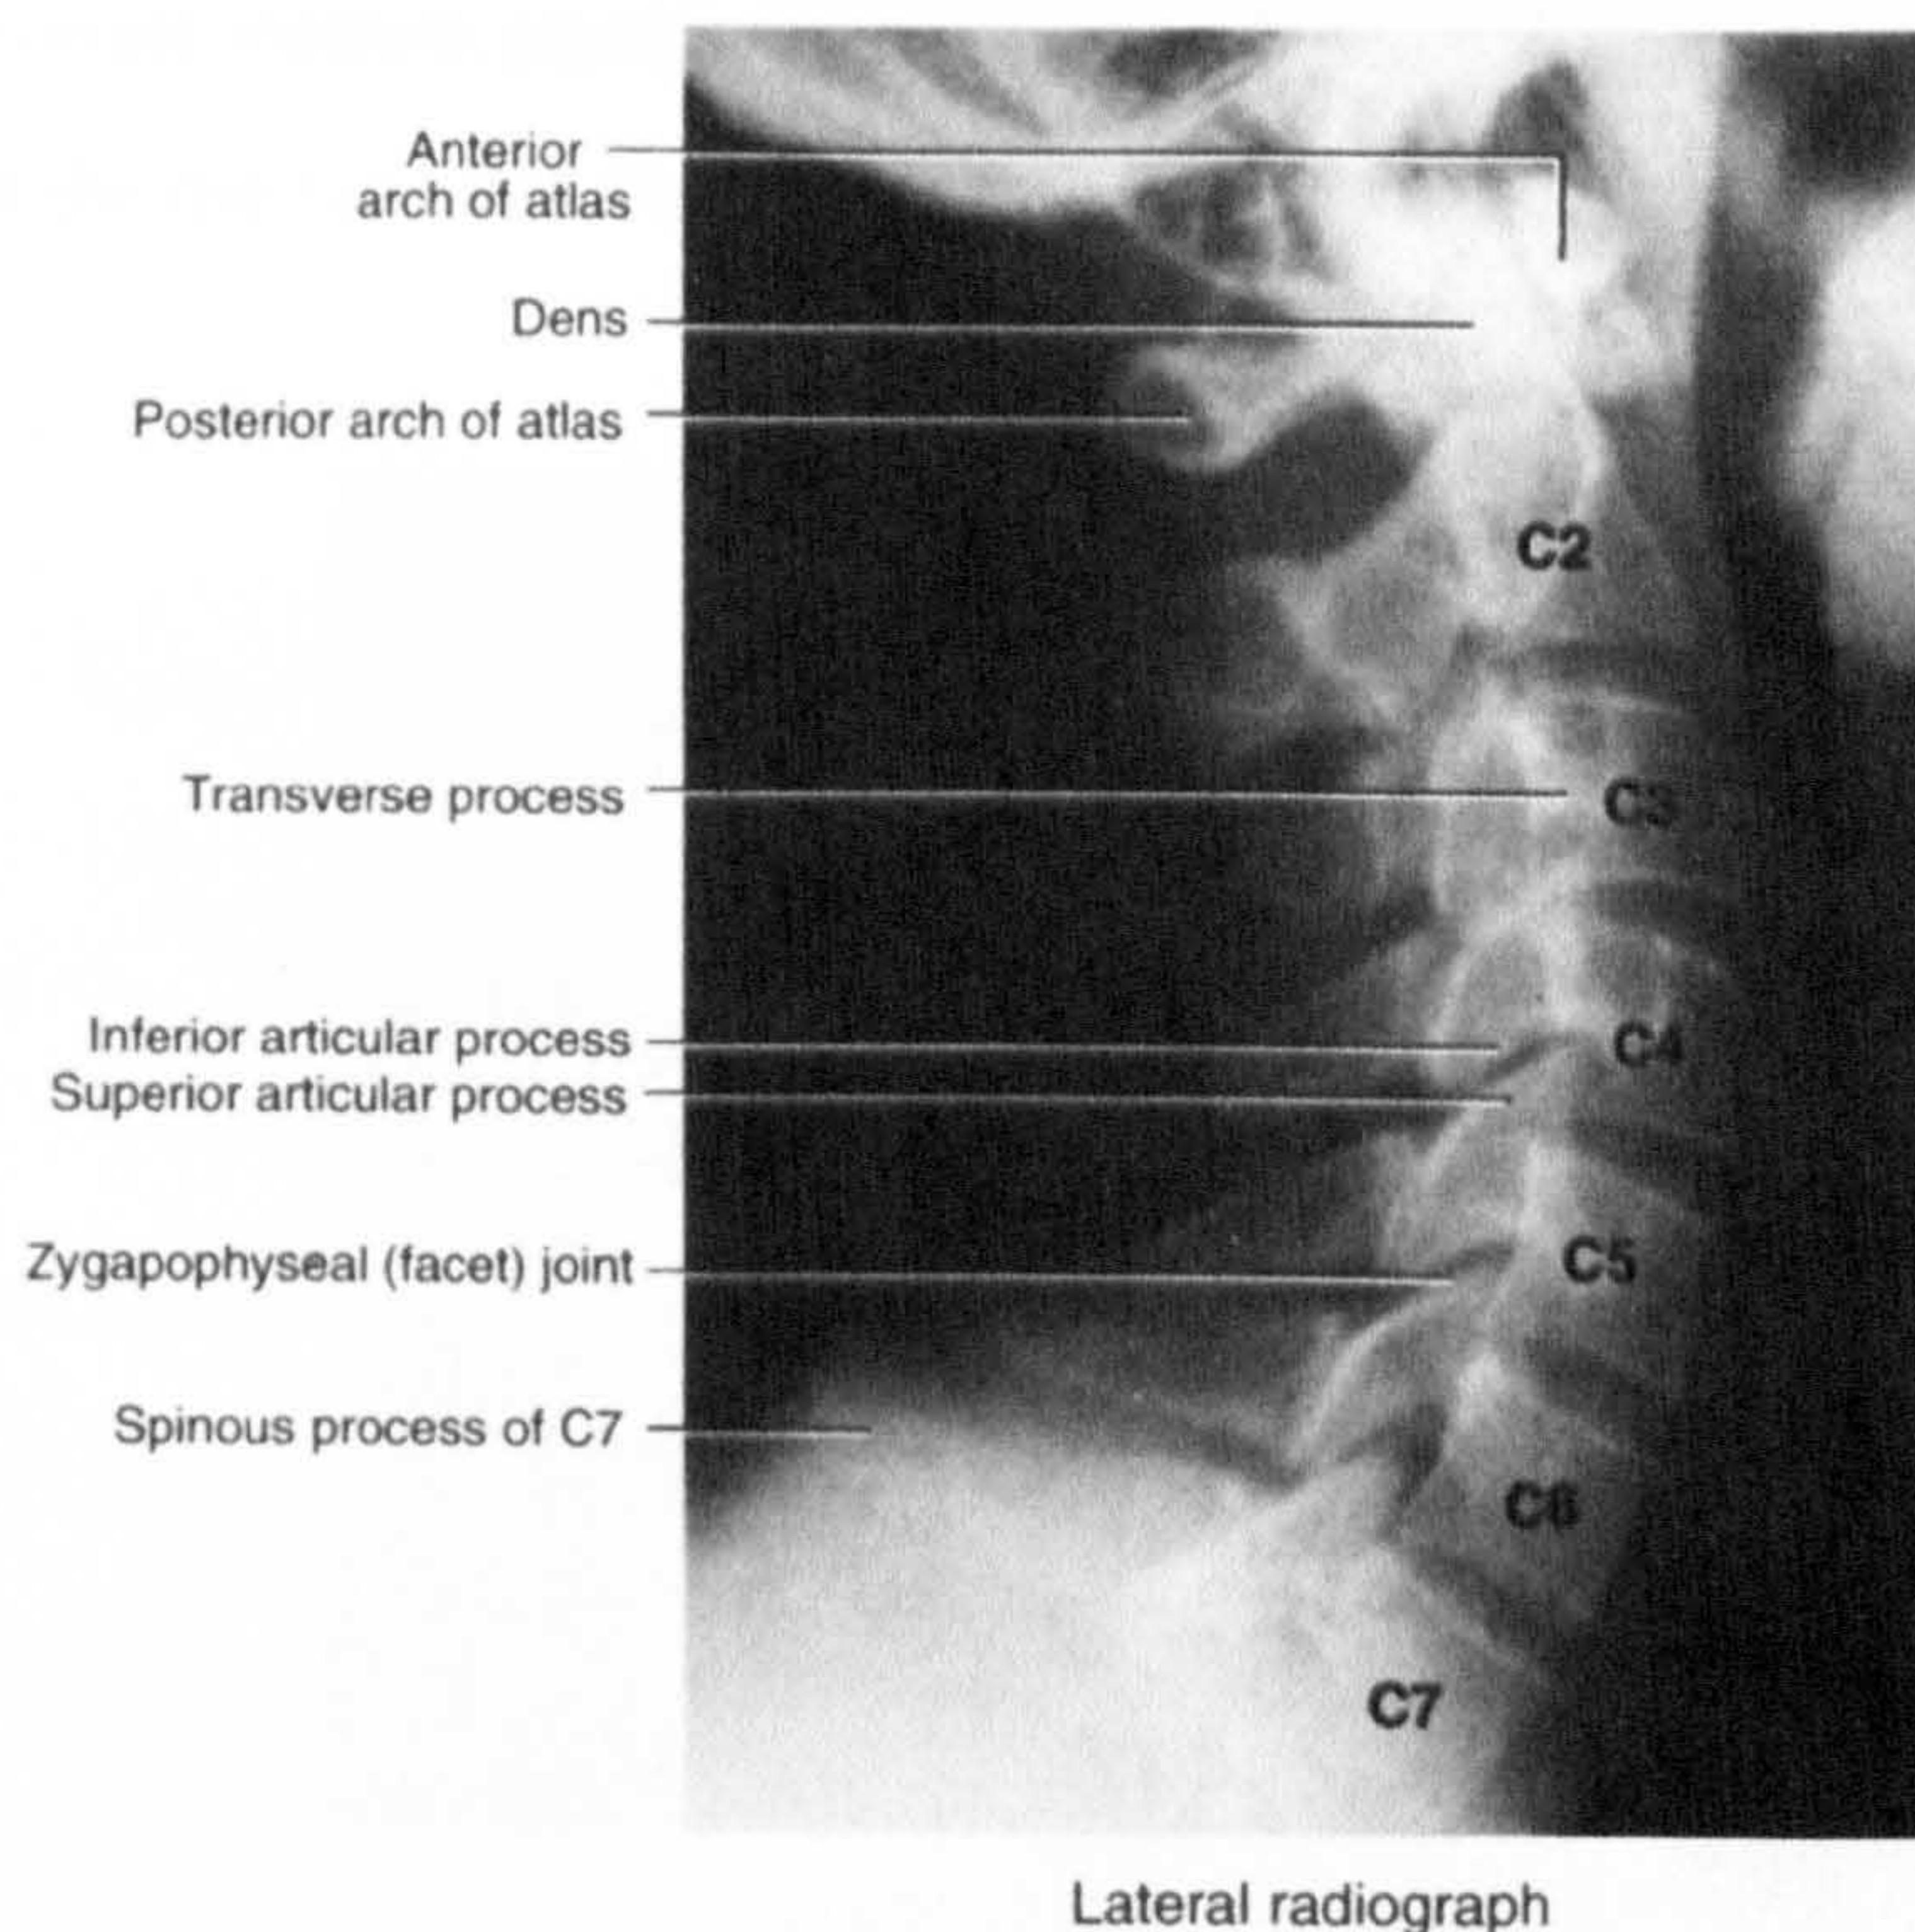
Plain radiograph of the neck
